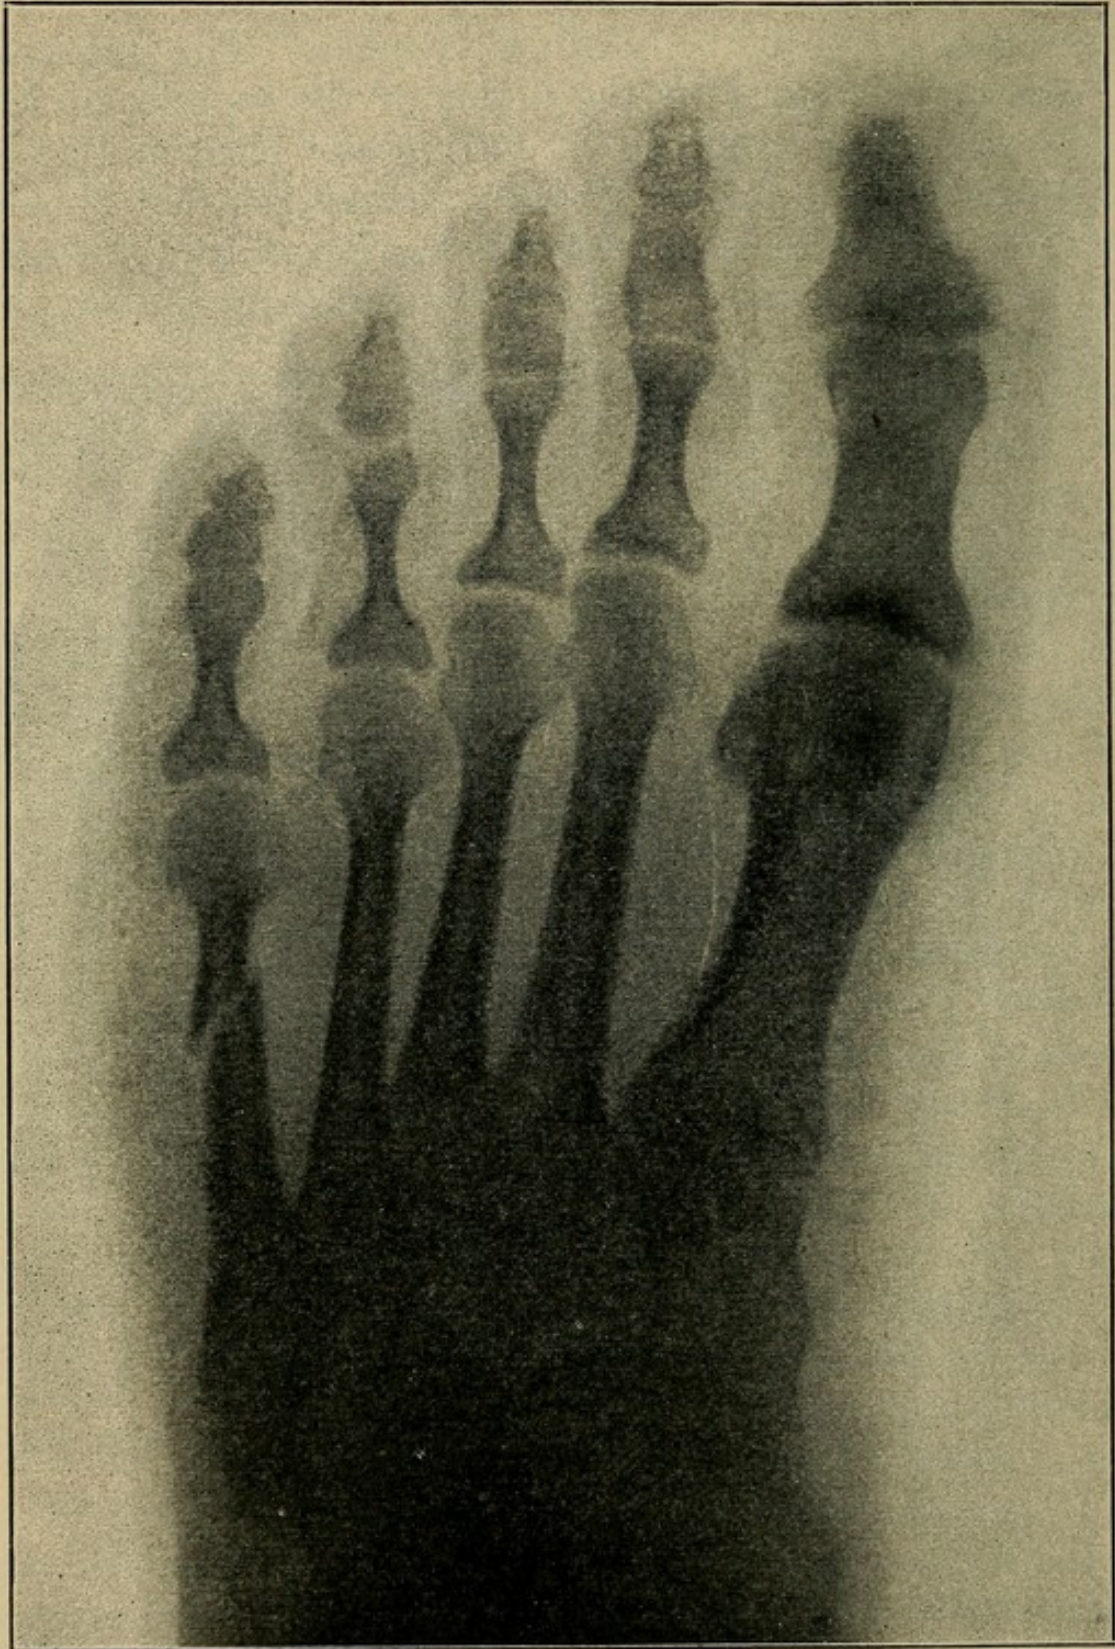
Fracture of the fifth metatarsal bone (X-ray). Fielitz, male, twenty-four years old. The injury was produced by a very heavy piece of iron falling on the foot. It is therefore a direct fracture or crushing-fracture of both phalanges of the big toe. Soft parts uninjured; marked swelling: Ordinary dressing; recovery.
